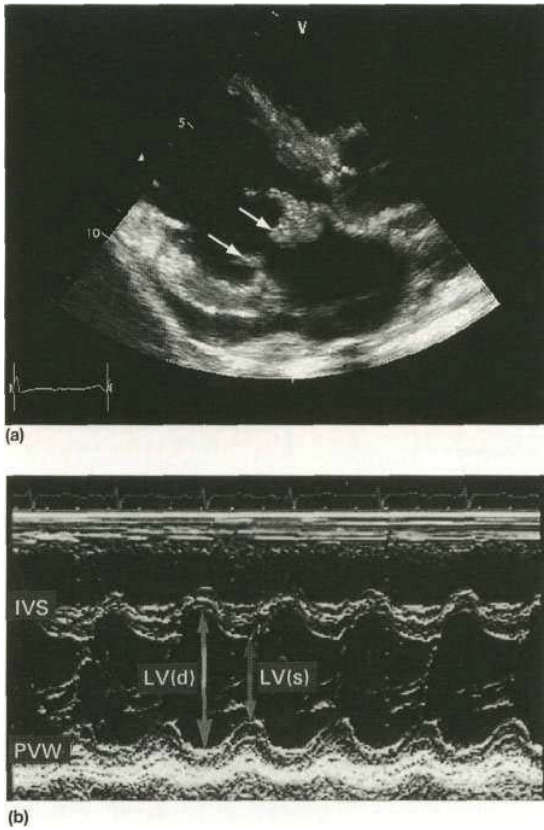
(a) Two-dimensional echocardiogram (long-axis view) showing vegetations (arrowed) attached to both the anterior and posterior leaflets of the mitral valve in a patient with infective endocarditis. (b) M-mode echocardiogram of the left ventricle demonstrating hyperdynamic contraction associated with volume overloading from severe mitral regurgitation in a patient with endocarditis. IVS, interventricular septum; LV(d) and LV(s), diastolic and systolic left ventricular dimensions; PVW, posterior ventricular wall.
